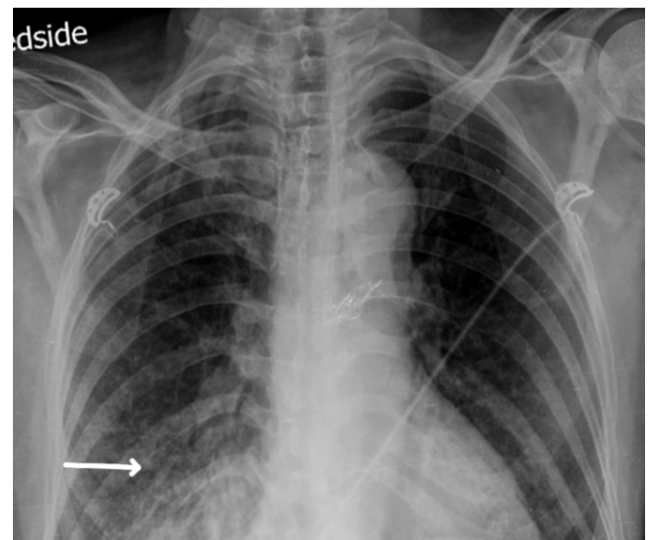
Post Bronchoscopic chest x-ray revealed reduced infiltrates over right lower zone (white arrow). (Images taken from the department of radiology, KMCH)
